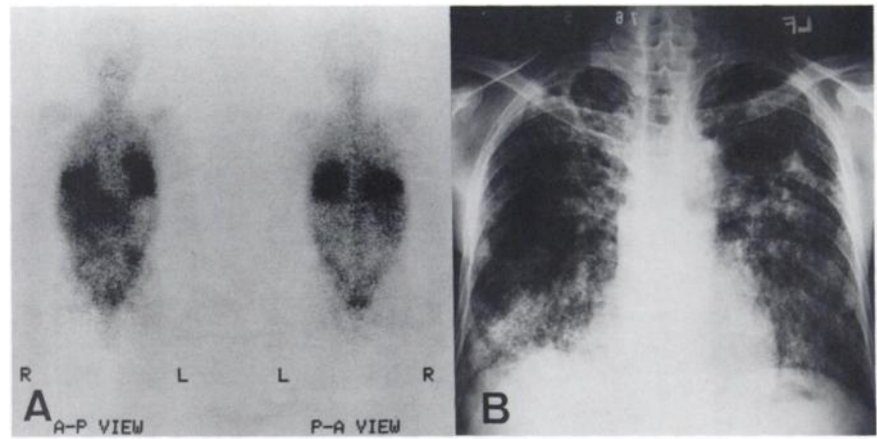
A 77-yr-old male patient. (A) The ^{67}Ga whole-body scan revealed diffused ^{67}Ga uptake in both lungs and (B) the chest x-ray demonstrated an abnormal miliary pattern.
